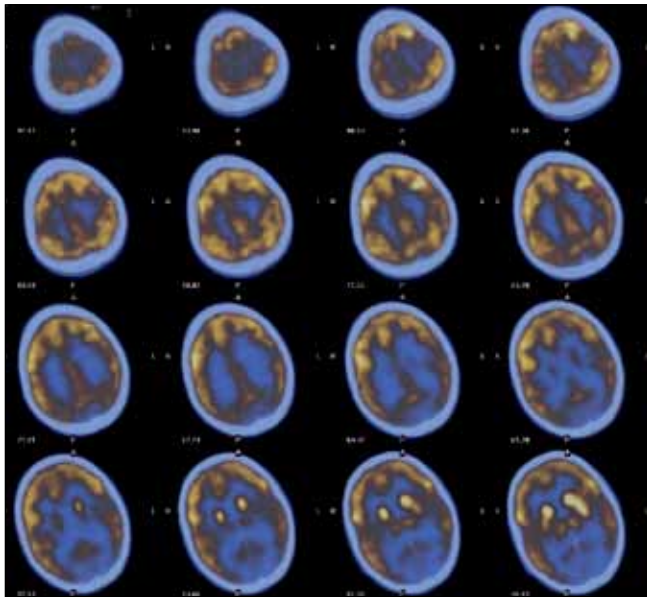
FDG PET-CT axial images of brain showing hypometabolism in the left temporal and bilateral occipital lobes
